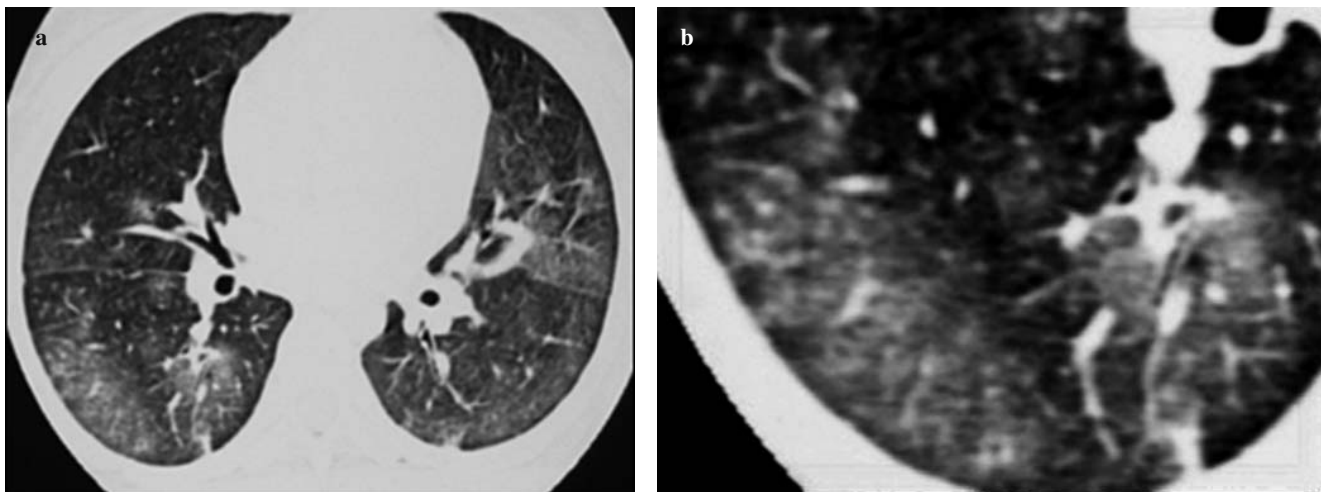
Inspiratory chest high-resolution computed tomography (HRCT) scan at the level of the lower lung fields with ground-glass opacities dominating bilaterally; b magnified view in which we can distinguish areas with bronchiolectasis at the lung periphery.
